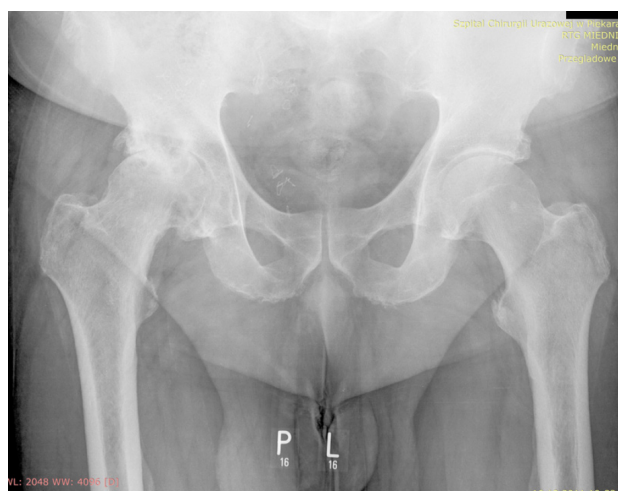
X-ray image showing hip arthrosis before total hip replacement surgery.
